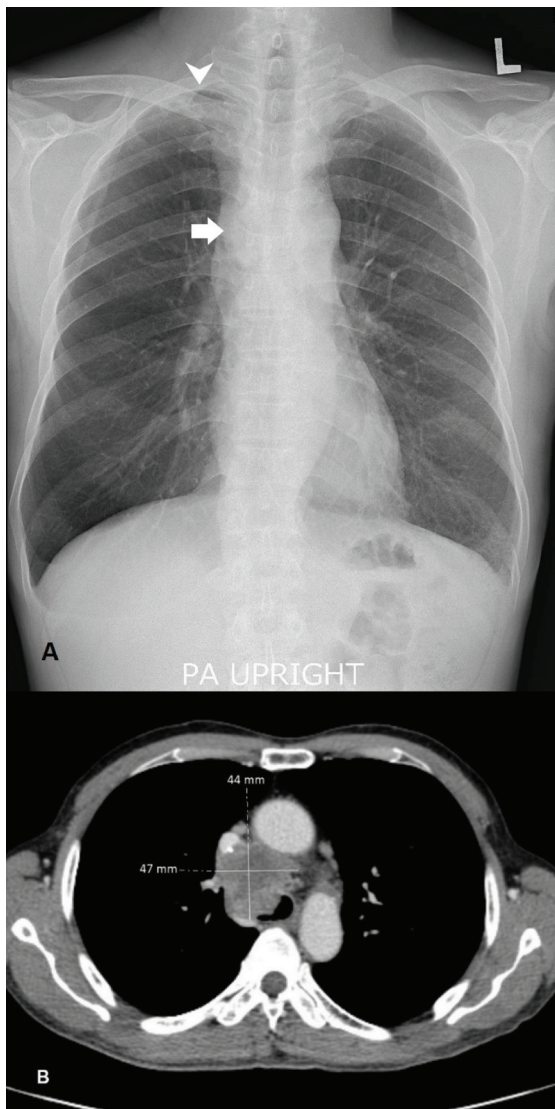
A 64-year-old man with non-massive hemoptysis for 60 days. (A) His first chest radiograph revealed reticulonodular infiltration at the right apical lung (white arrowhead) with suspicion of an enlarged right hilar lymph node (white arrow). (B) CT scan on the next day after the first visit showed an irregular border and heterogeneous enhancing mass at the right lower paratracheal area, invading the trachea and right main bronchus, causing mimic enlarged hilar lymph node on a plain radiograph.
